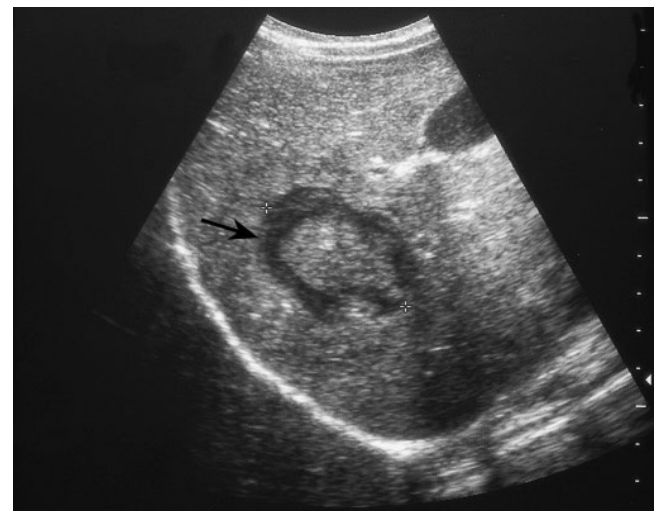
This hepatic ultrasound demonstrates an abscess in a patient with abdominal pain and hepatic tenderness.
